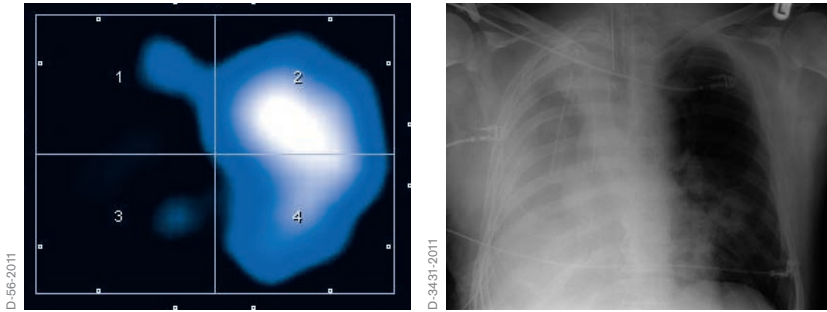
Tidal image and corresponding chest X-ray of a patient with pneumonectomy
